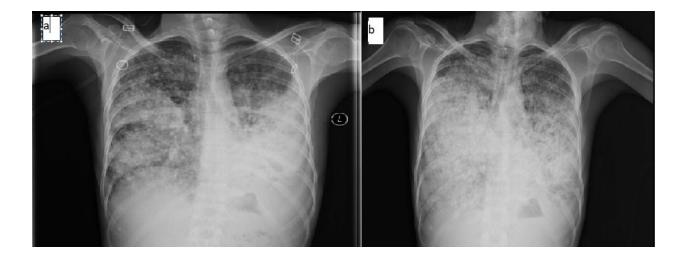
a) Chest X-ray Postero-Anterior (PA) view showed left side consolidation with right side mid and lower zone nodules. b) Bilateral midzone and lower zone non-homogenous opacity with nodules, which has progressed from initial admission.
